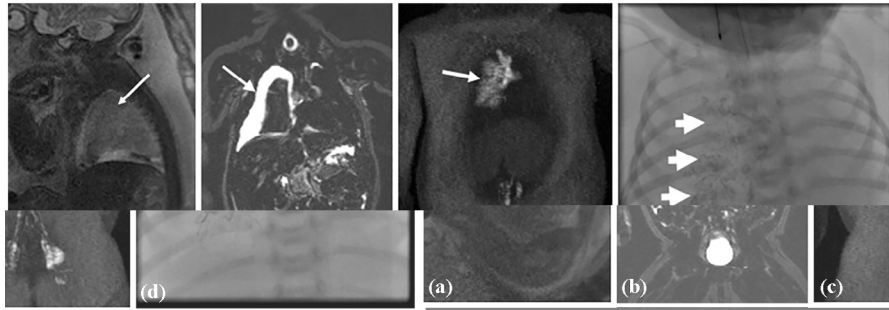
Neonatal chylothorax. (a) Sagittal T2 single shot FSE image of a 24-week fetus demonstrating tubular high signal structures in the lungs (arrow), characteristic of “nutmeg lung” along with a right pleural effusion. (b) Coronal T2-weighted image at 20 days of life demonstrates a right pleural effusion (arrow). (c) Maximum intensity projection (MIP) from a dynamic contrast-enhanced MR lymphangiogram at 20 days of life shows lymphatic perfusion of the right lung (arrow) corresponding to the area of pleural effusion. (d) Conventional lymphangiography at 20 days of life demonstrates the flow of oil-based contrast into the pathologic lymphatic channels of the right lung (white arrows).
